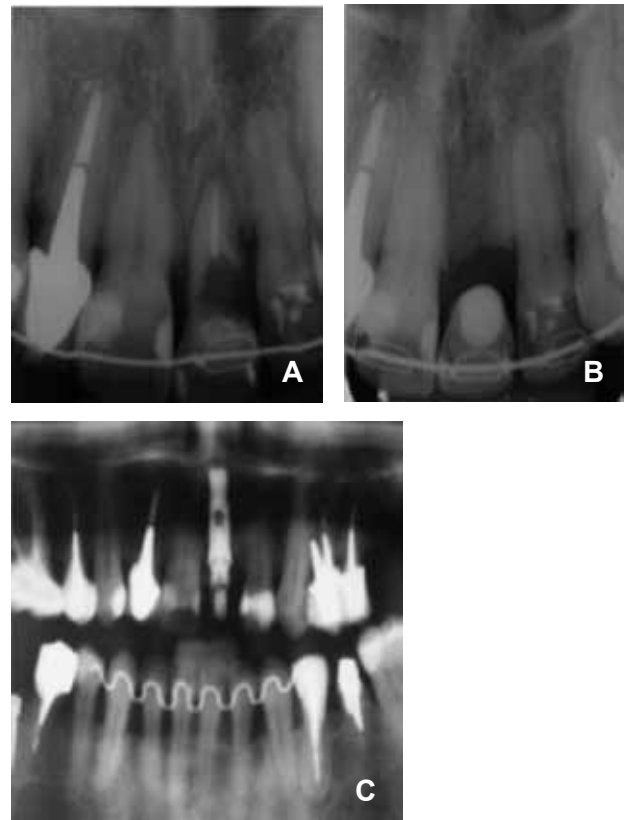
Case 1: A) Initial periapical radiograph showing presence of internal resorption. B) Retention with temporary fixed appliance. C) Panoramic radiograph with implant on tooth 21.
